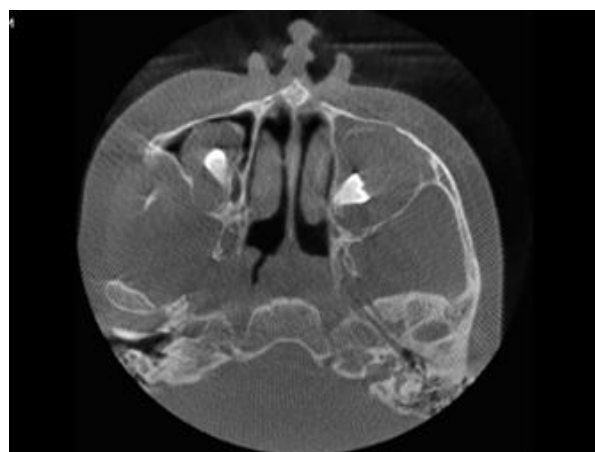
CBCT – radiolucent lesions in relation 18,28 teeth
